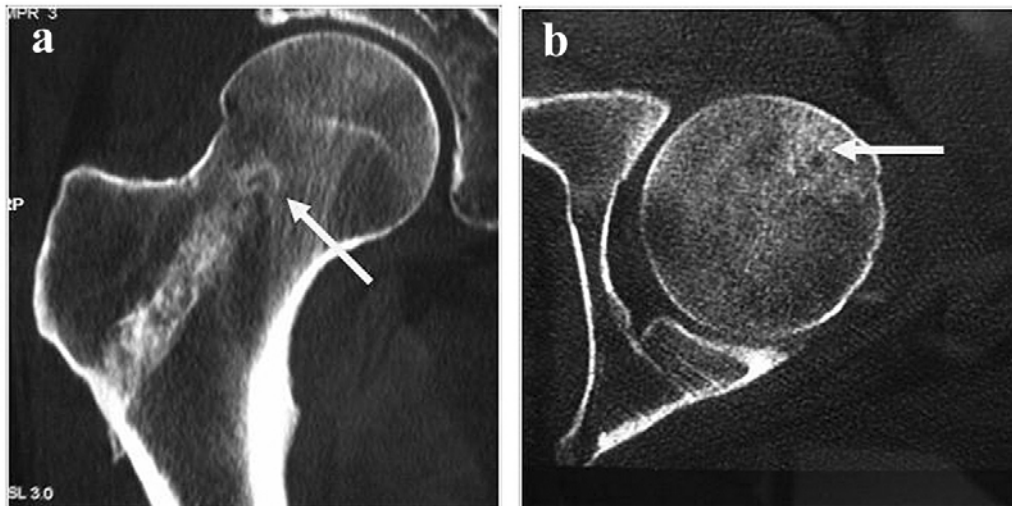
Follow up CT images (Case 1). CT imaging also at 6 month follow up. (a) Coronal and (b) Axial slices at the midsection of the site previously occupied by the cyst.
